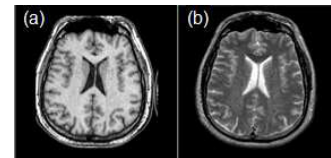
healthy (a) T1- and (b) T2-weighted brain MR image slices in axial view showing the lateral ventricles, images courtesy of [10].
